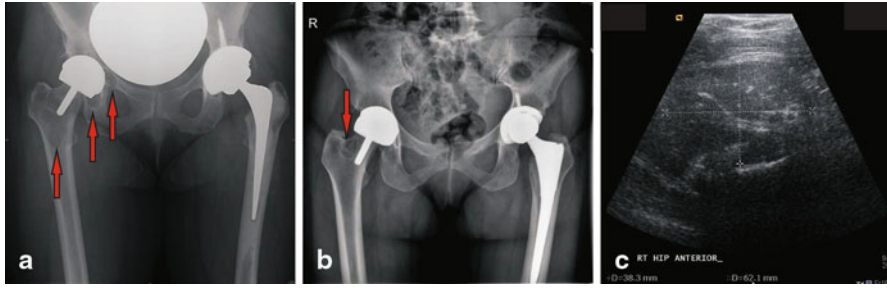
Radiographic appearances of lytic areas around prosthesis (a, b). c Ultrasound scan findings around hip in radiograph a
